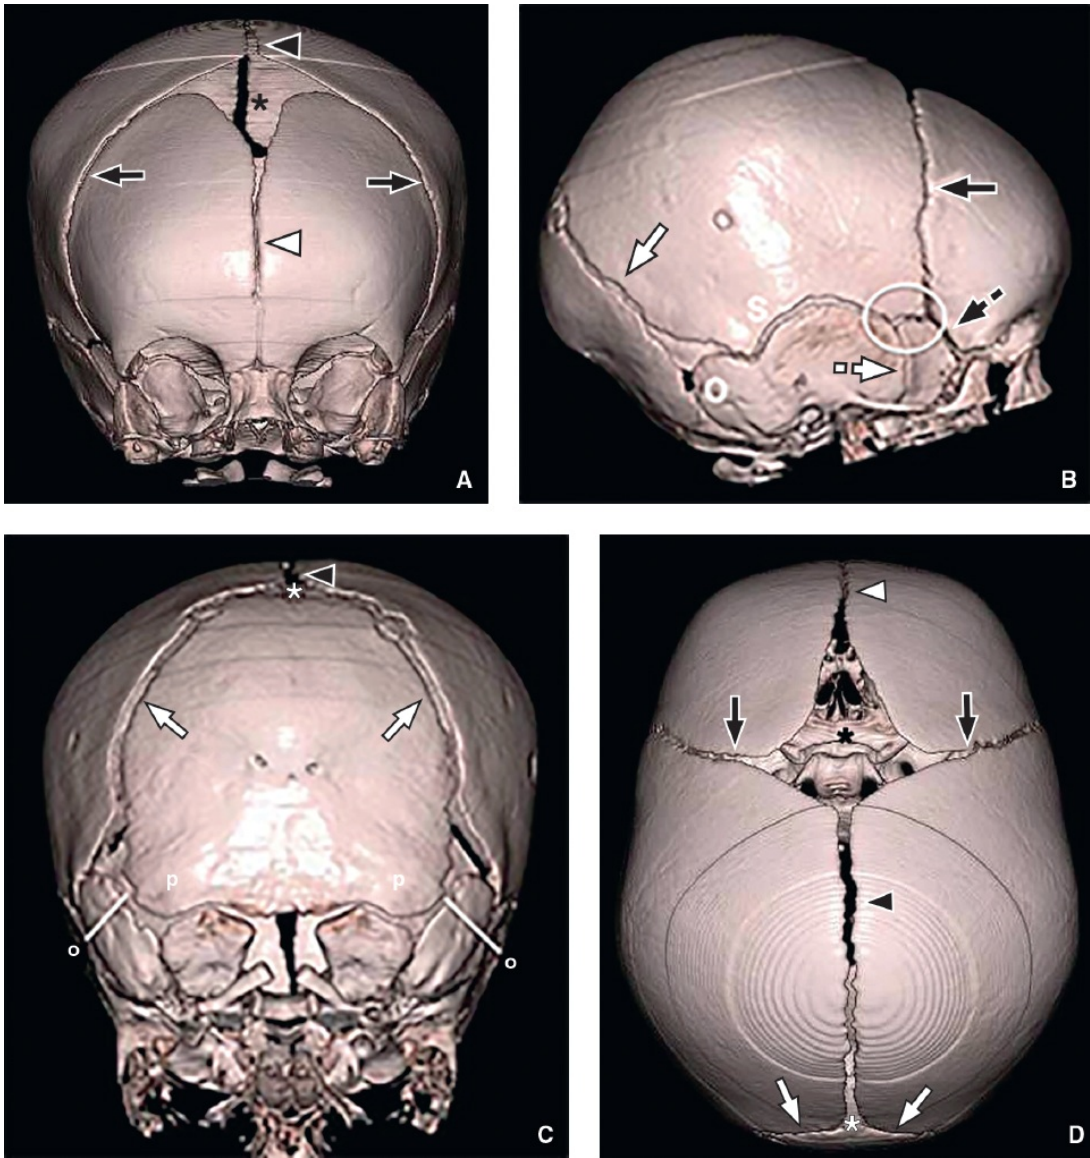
Three-dimensional surface renderings of a head CT from a normal 3-month-old boy evaluated for craniosynostosis: frontal (A), lateral (B), posterior (C), and superior (D) views. Annotations as for Figure 1.1 with additional markings of pterion with a circle, squamous (temporoparietal) suture with “s,” sphenotemporal suture with *white dashed arrow*, frontosphenoid suture with *black dashed arrow*, occipitomastoid suture with “o,” and posterior intraoccipital synchondrosis with “p.”
